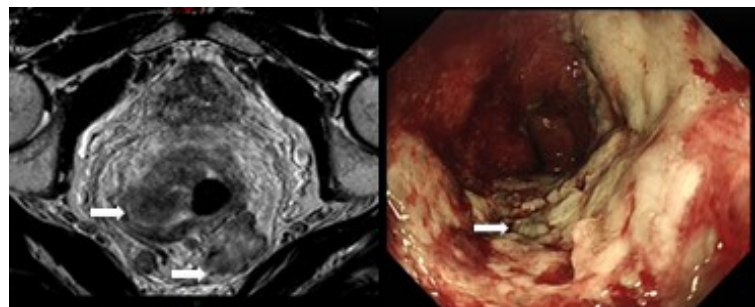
Week 12 MRI pelvis and endoscopy with significant residual disease. Tumour indicated by white arrow
